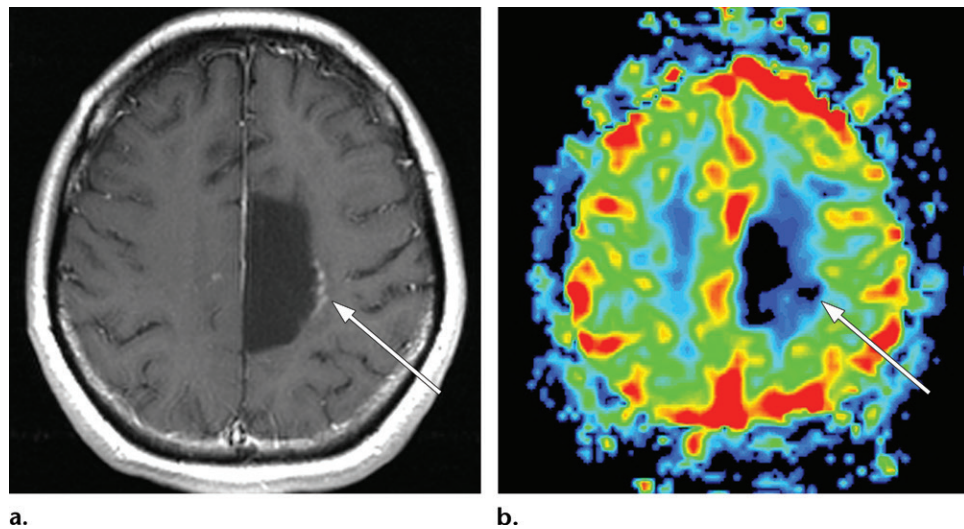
Radiation necrosis in a 48-year-old woman with slowly progressive right-sided weakness after surgical resection and RT (standard-fractionation type) for a left parietal lobe astrocytoma. (a) Axial contrast-enhanced T1-weighted image shows an enhancing lesion (arrow) around the resection cavity. (b) Relative cerebral blood volume (rCBV) map from dynamic susceptibility contrast (DSC) perfusion MRI shows reduced rCBV (arrow).
